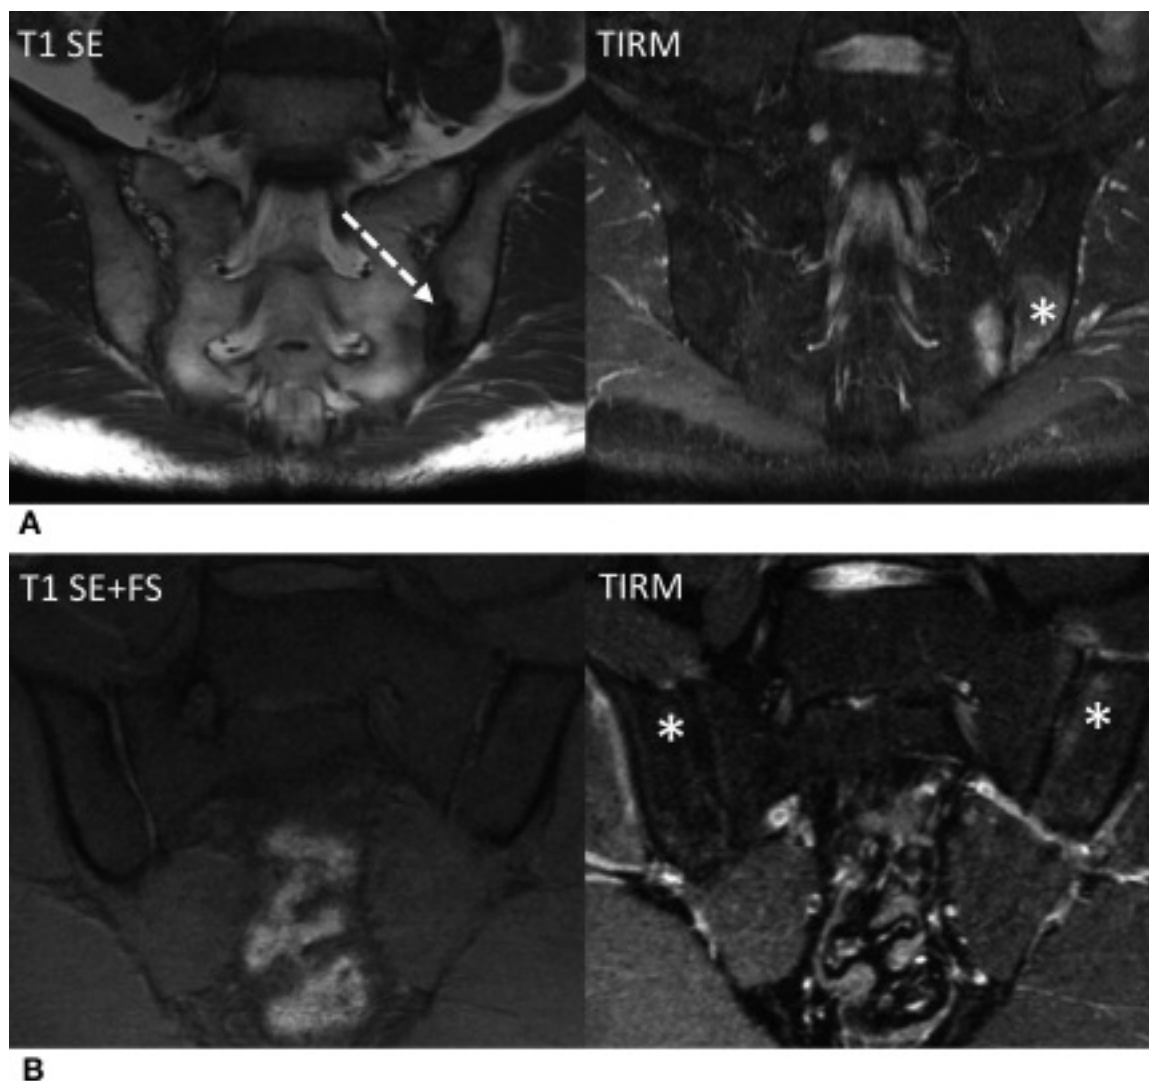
A. Representative T1 SE (left) and TIRM (right) images show erosive changes (broken arrow) and bone marrow edema (*) on MRI of sacroiliac joints in a patient later diagnosed with AS. B. In comparison to panel A, representative T1 SE + FS (left) and TIRM (right) images on MRI of sacroiliac joints of a patient later diagnosed with psoriatic arthritis show only bone marrow edema (*), but no erosive changes.
